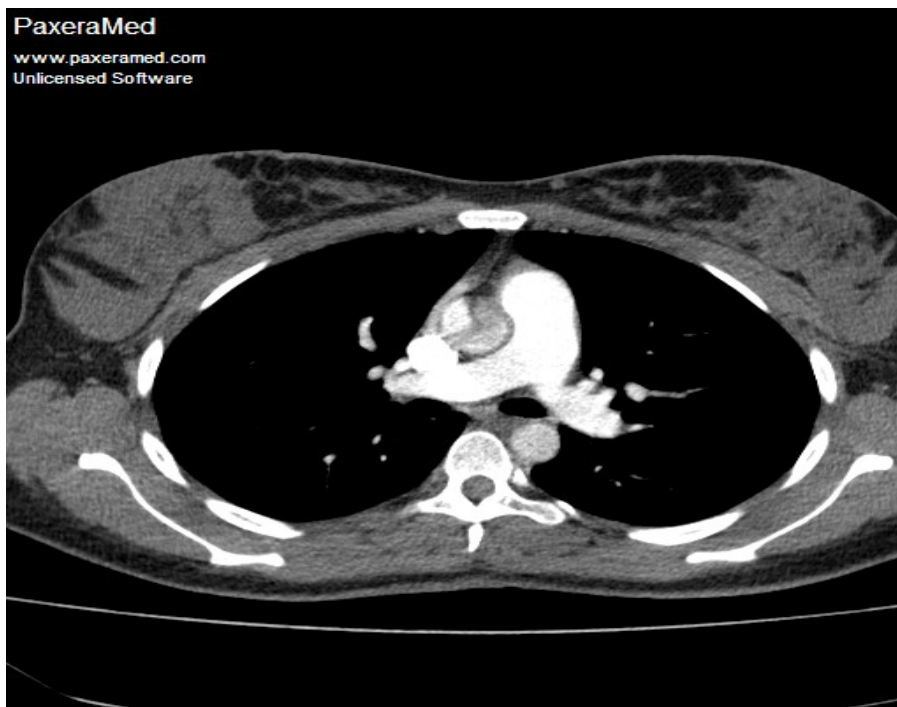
9 Sixty-four slice MDCT in a 55-year-old man with Normal CT appearance of the pulmonary vessels.
